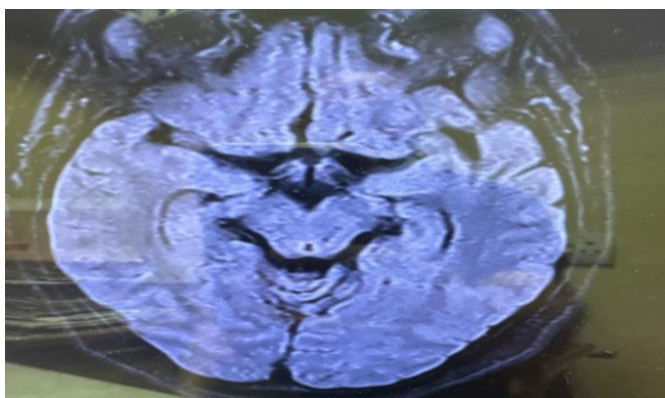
Axial FLAIR MRI scan of the brain, demonstrating a large, hyperintense lesion in the left temporal lobe
